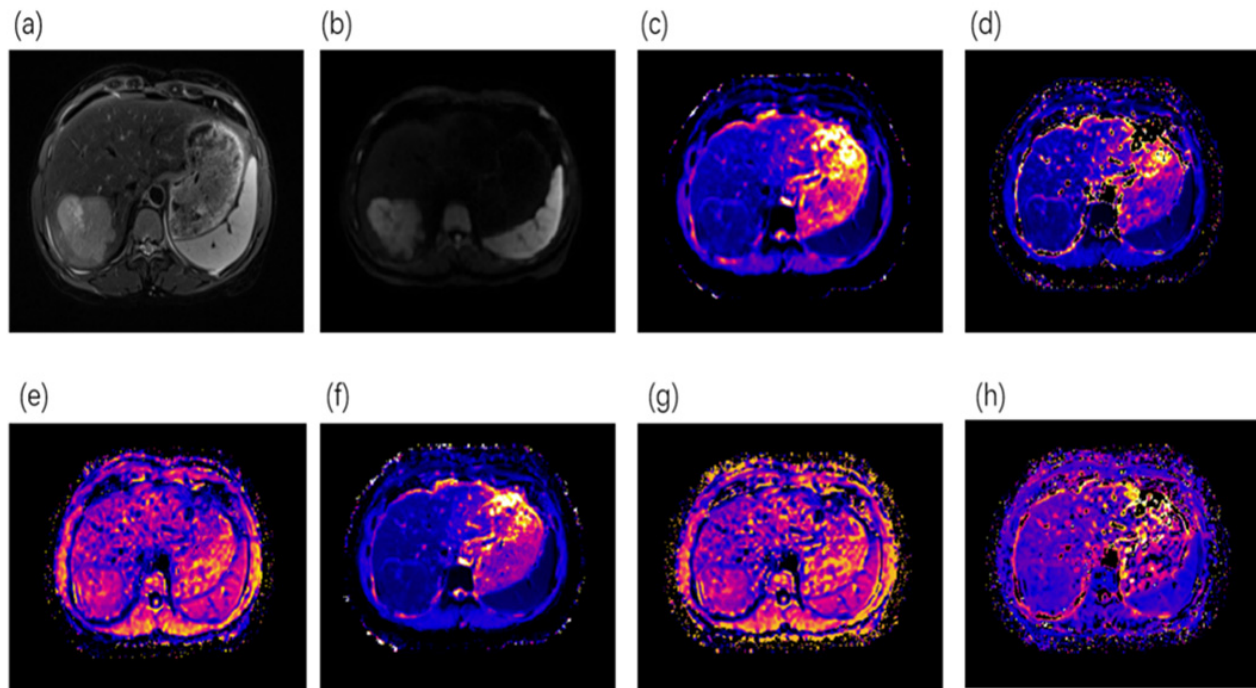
MRI images of a patient with pathologically confirmed hepatocellular carcinoma.
